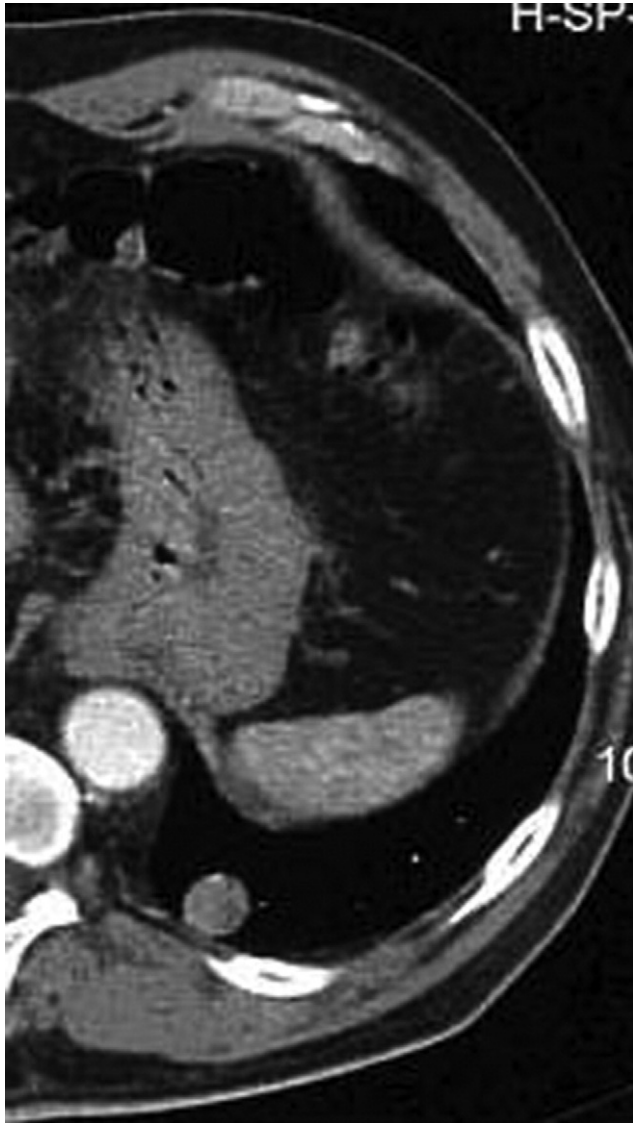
Baseline contrast-enhanced chest CT scan in a patient with a pulmonary metastasis verifies the presence of a lung nodule within the left lower lobe.
